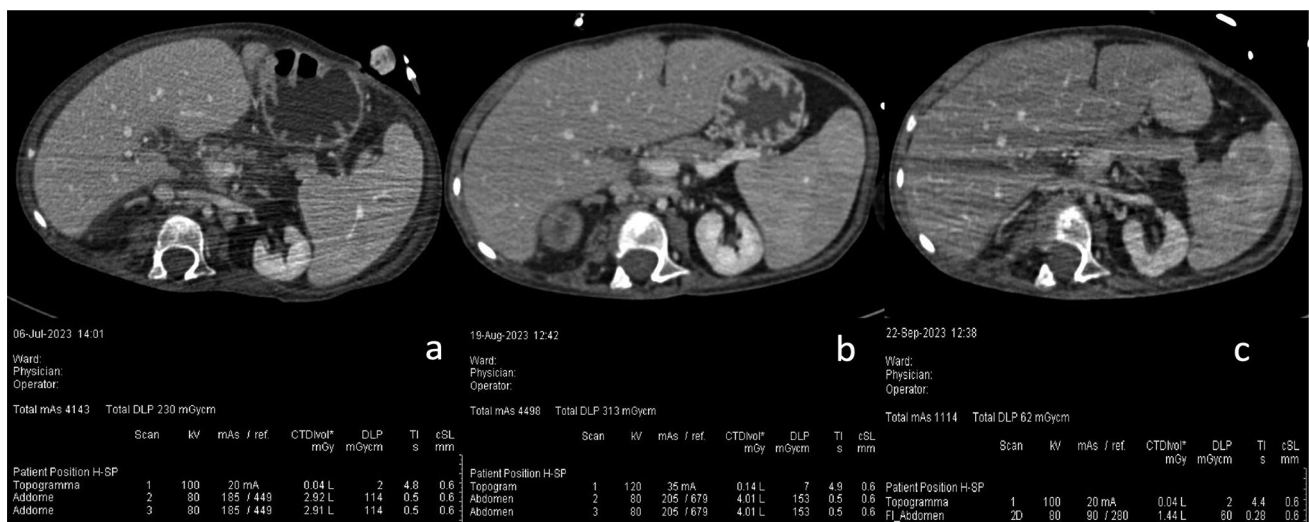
Male, 6 years old (22 kgs). The same patient had three abdominal CT studies (a, b, c) at three different dates respectively with the same equipment and clinical task (peritoneal abscesses, right kidney stones). The exams were performed using different protocols, exposure settings and with variability in the number of phases
